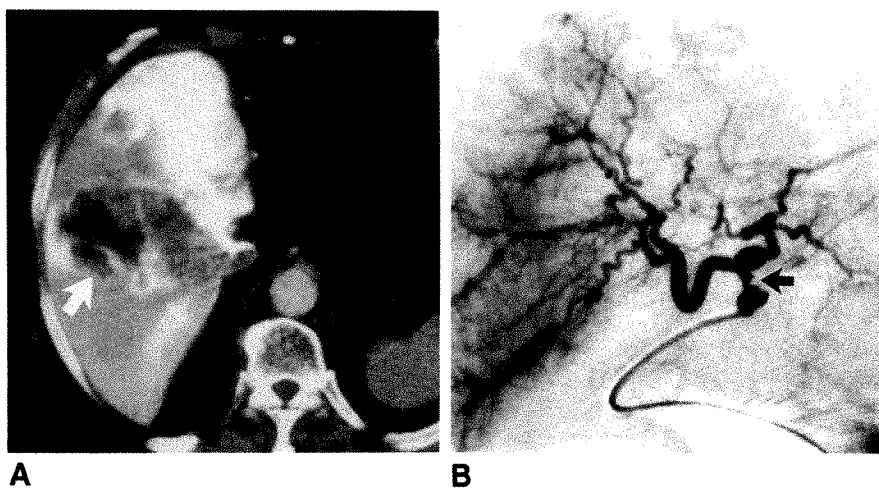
A, Intraarterially enhanced CT scan obtained after 6 months of intraarterial infusion chemotherapy. Left lobe of liver has been resected. Arterial perfusion of liver area surrounding large metastases (arrow) is markedly reduced compared with that in anterior portion of liver.
